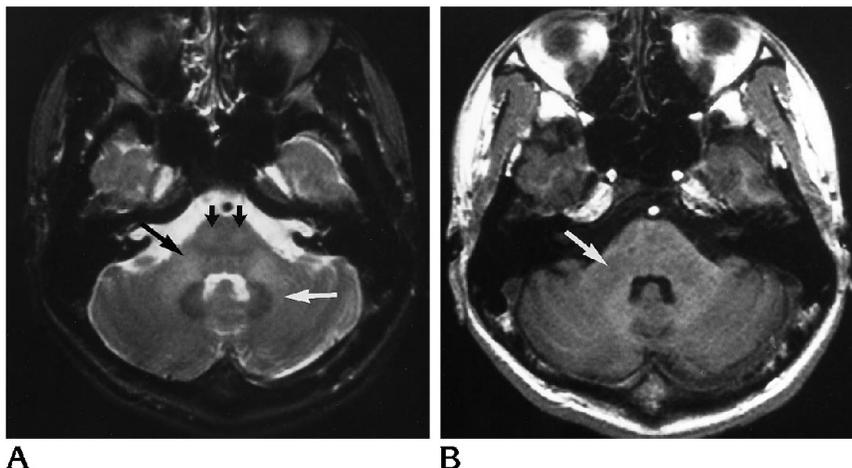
White matter hyperintensities in the brain stem and cerebellum on T2-weighted images in restricted white matter change (patient 5).
